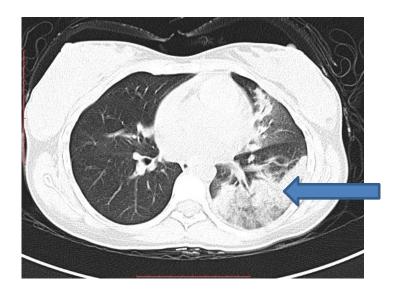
CT scan images of 38-year-old female with positive RT-PCR. Axial thinsection unenhanced CT scan shows left lower lobe large patchy pulmonary consolidation opacity. (Z. Cheng et al., 2020)
